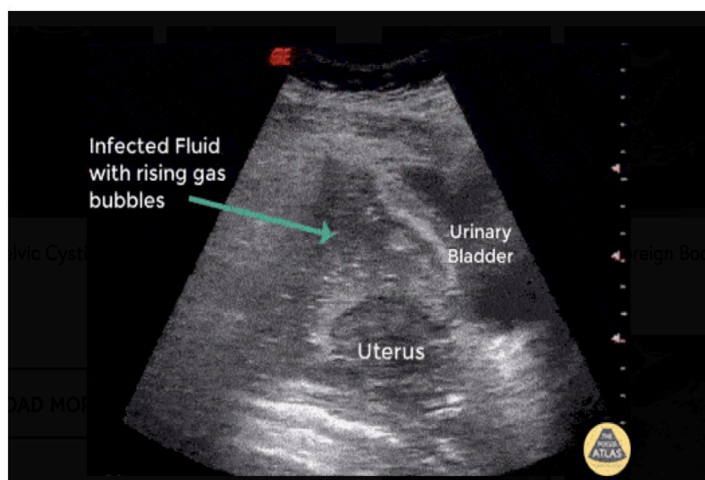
Ultrasound demonstrating pelvic free fluid and rising gas bubbles, indicative of uterine perforation. Image courtesy of Robert Jones, DO, POCUS Atlas. Available at <https://www.thepocusatlas.com/ob-gyn-atlas>.
